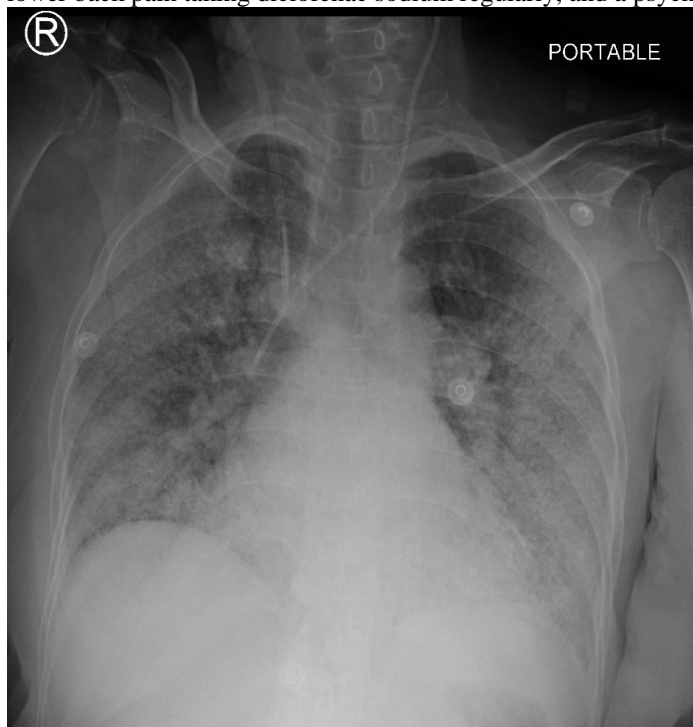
A semi-erect anteroposterior (AP) portable chest X-Ray showing bilateral infiltrates, suggestive of COVID pneumonia.
